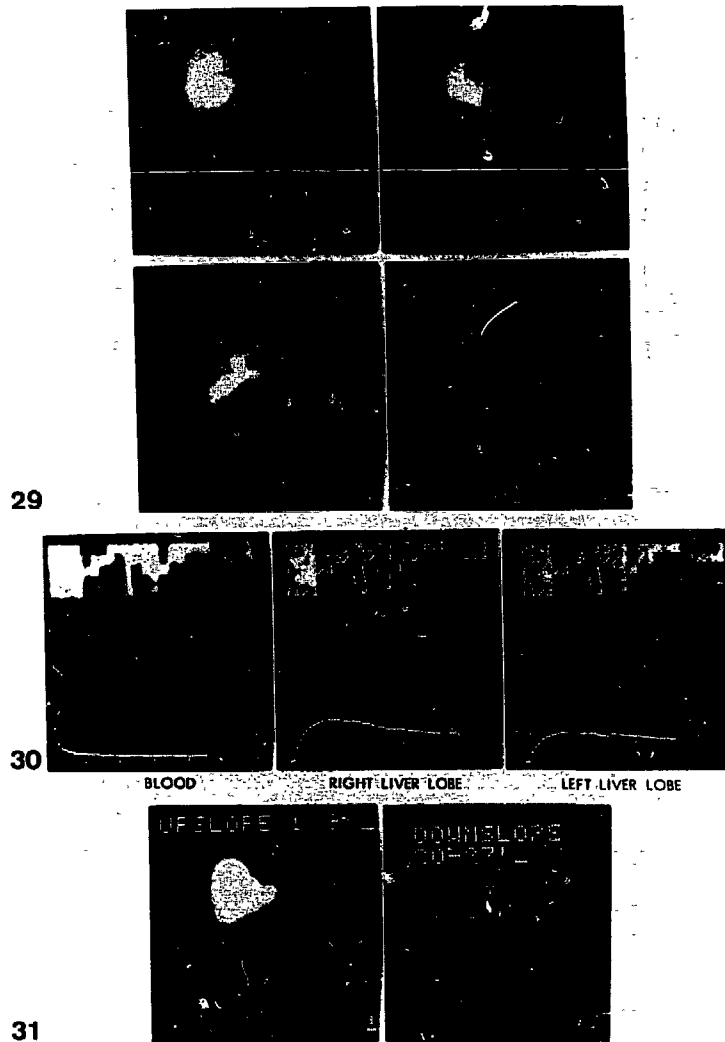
29-31 Cholescintigraphy in a patient with drug induced hepatitis; after clinical improvement.
